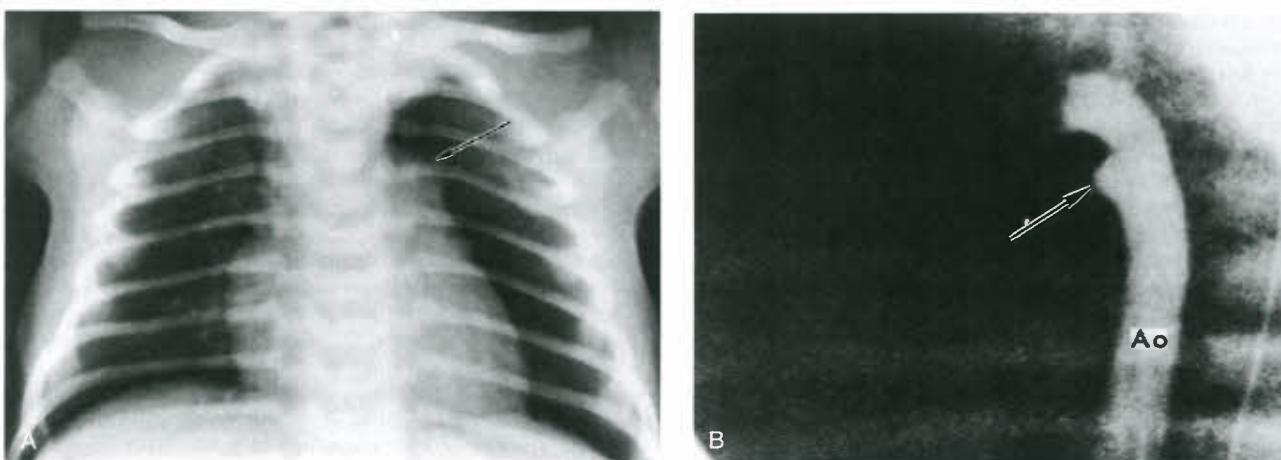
A: Posterior-anterior chest roentgenogram of a 2-day-old infant demonstrating the ductus bump (arrow). B: Angiogram in the lateral position of a 5-day-old infant demonstrating the ampulla of the ductus arteriosus (arrow). Ao, aorta.
